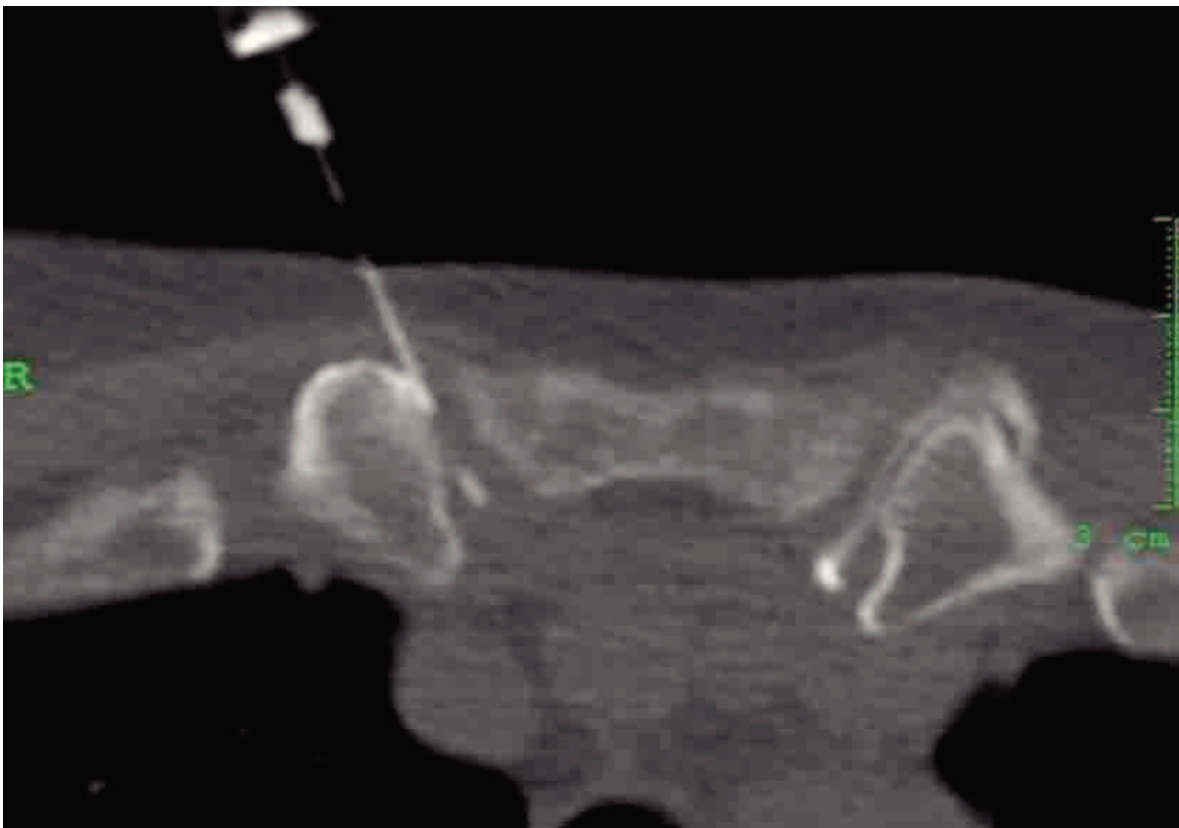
[22] CT-guided sternoclavicular joint injection: Peterson C, Hodler J. Adverse events from diagnostic and therapeutic joint injections: a literature review. *Skeletal Radiol.* 2011 Jan;40(1):5-12.
